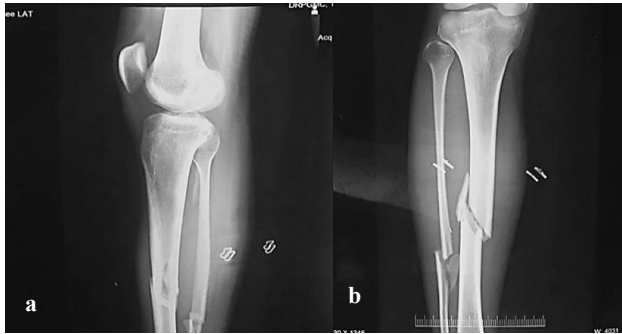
(a and b): Anteroposterior and lateral radiographs of the leg demonstrating a midshaft tibial fracture with minimal displacement associated with an ipsilateral fibular shaft fracture.
